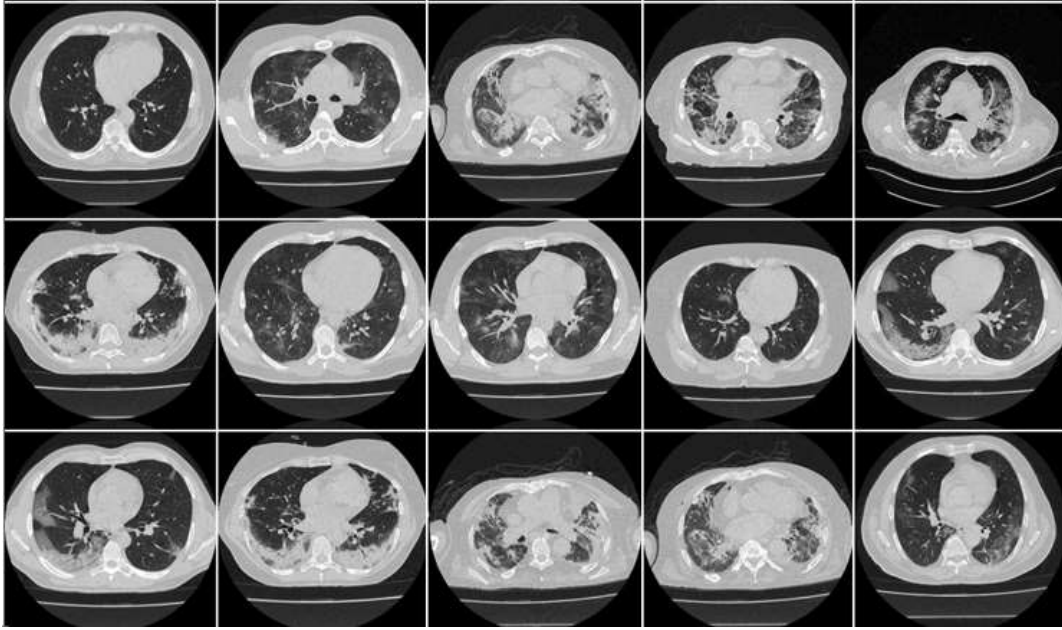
Raw “COVID-19 CT lung slices” taken from the CroMED dataset.
